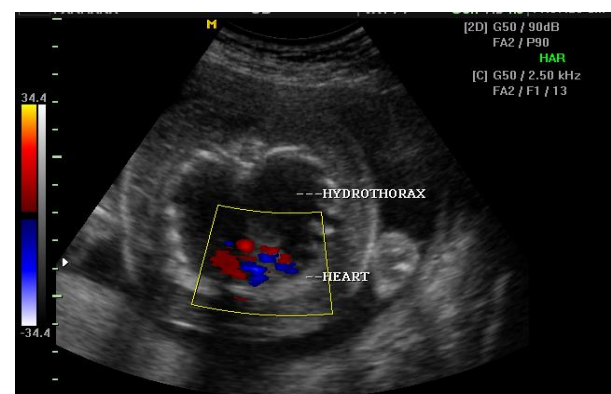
Doppler sonography showed hydrothorax around the fetal heart
